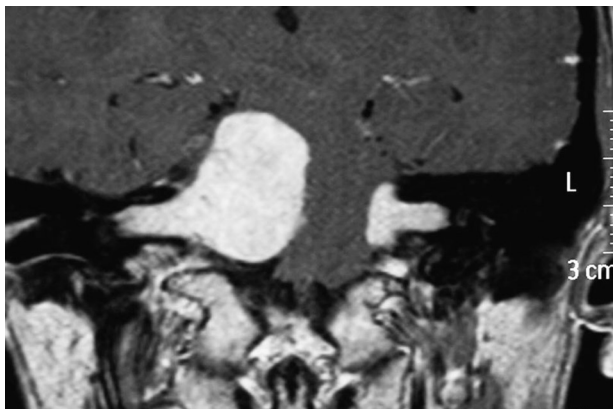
Coronal T1-weighted MRI with contrast of NF2 patient with bilateral VS.
